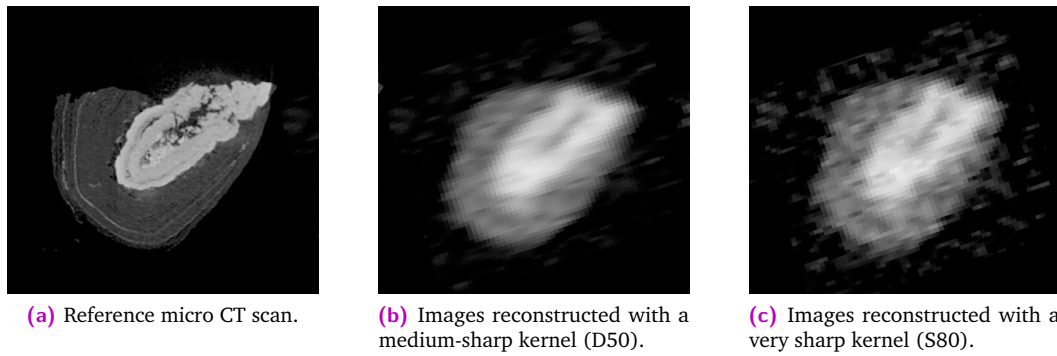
Visual assessment of internal stone morphology with different reconstruction kernels for the HR mode of the PCD-CT system. Clinical dose level used to obtain HR PCD-CT images.
